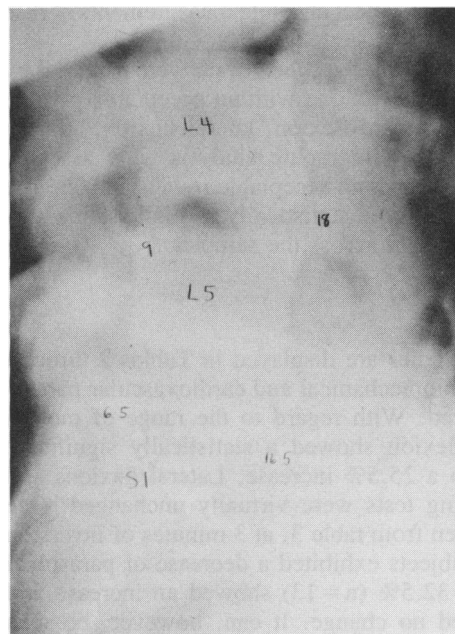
Patient #1. Pre-Inversion radiograph.
